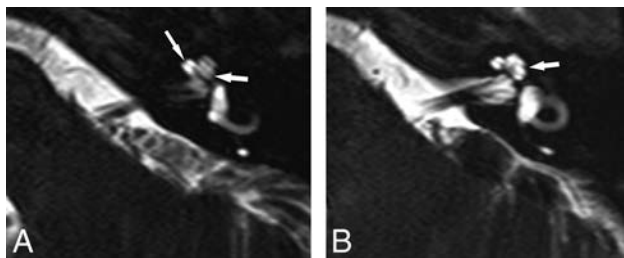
Axial 3D T2-weighted images from inferior to superior showing a normal osseous spiral lamina and interscalar septum. A, A normal osseous spiral lamina separating the scala tympani (posterior) and scala vestibuli (anterior) of the basal (anterior arrow) and middle turns (posterior arrow). B, A normal lateral R2 notch (arrow) associated with the second part of the interscalar septum between the upper basal and upper middle turns of the cochlea.
